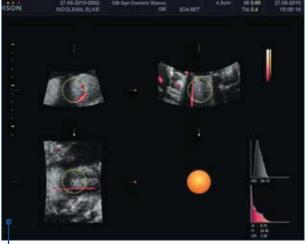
3D power Doppler ultrasound - 28 WA
